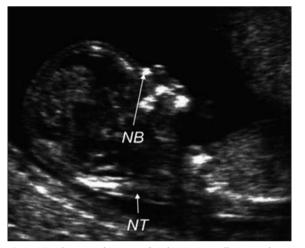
Ultrasound image of a chromosomally normal fetus at 12 weeks with normal nuchal translucency thickness (*short arrow*) and an observable nasal bone (*long arrow*).
